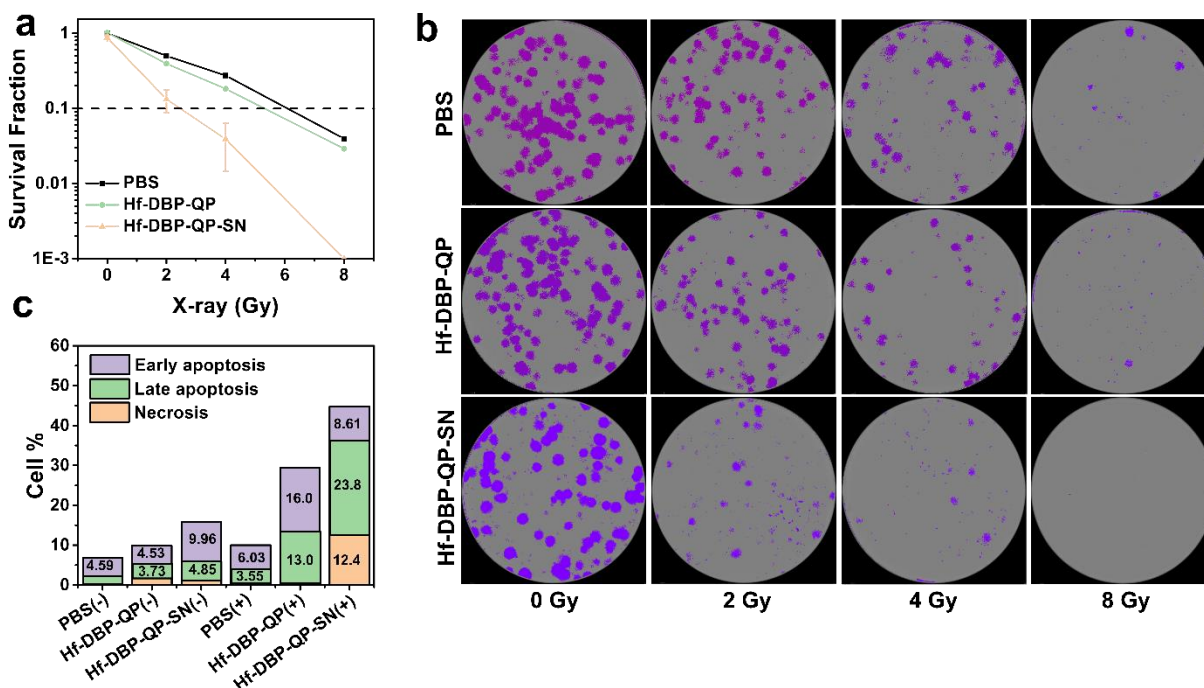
Clonogenic assay and immunogenetic cell death. (a) Clonogenic assays showing radioenhancement of Hf-DBP-QP and Hf-DBP-QP-SN on CT26 cells upon the radiation of different doses of X-rays (n=3). (b) Respective images of colony formation of CT26 cells after treated with Hf-DBP-QP or Hf-DBP-QP-SN followed by 250 kVp X-ray irradiation. (c) Quantification of early apoptotic, late apoptotic, and necrotic CT26 cells after incubation with Hf-DBP-QP or Hf-DBP-QP-SN with or without X-ray radiation (X-ray dose: 3 Gy).
